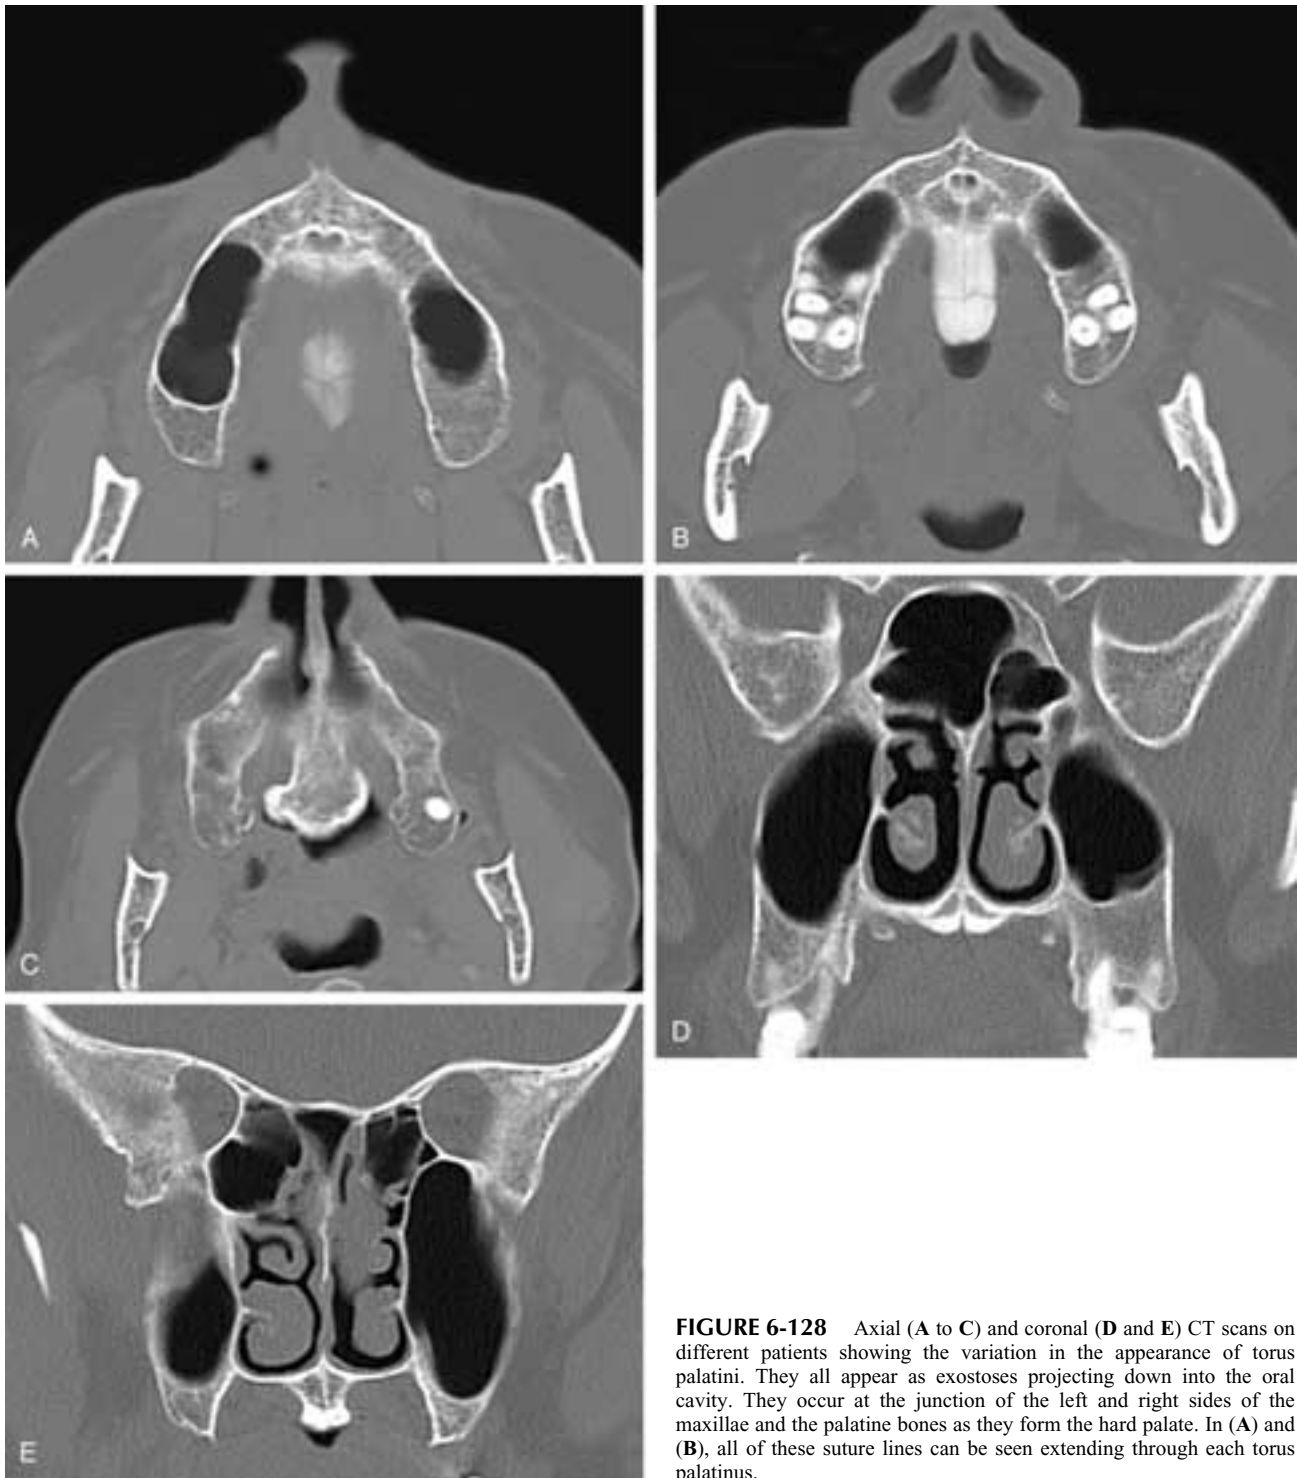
Axial (A to C) and coronal (D and E) CT scans on different patients showing the variation in the appearance of torus palatini. They all appear as exostoses projecting down into the oral cavity. They occur at the junction of the left and right sides of the maxillae and the palatine bones as they form the hard palate. In (A) and (B), all of these suture lines can be seen extending through each torus palatinus.
